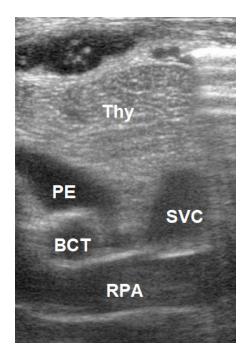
Parasternal transversal view: superior venae cava (SVC), brachiocephalic trunk (BCT), right pulmonary artery (RPA), pericardial effusion (PE).
